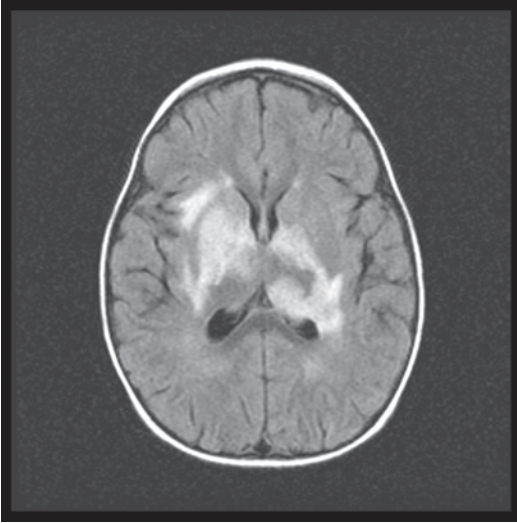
Axial T2 FLAIR MRI showing bright lesions consistent with acute disseminated encephalomyelitis (ADEM) in a 3-year-old who presented with chorea and difficulty walking 3 weeks after a viral illness (Courtesy of Blaine Hart, MD)
